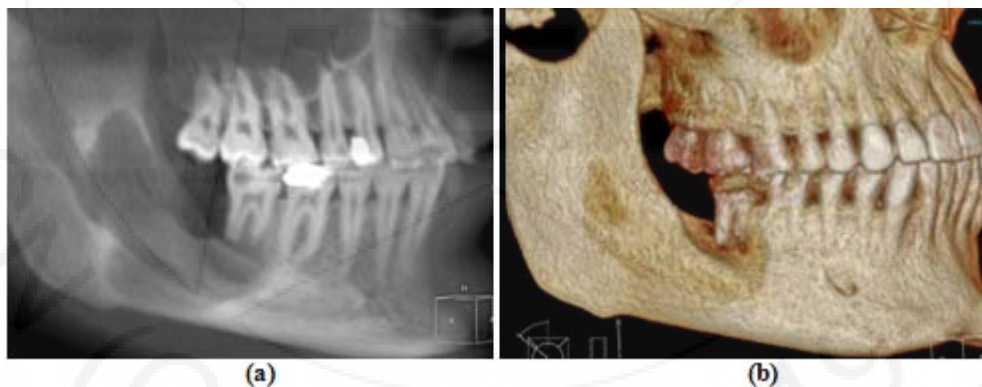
Preoperative CBCT. Sagittal slice (a) and 3D images (b) presenting the osteolytic defect from ameloblastoma in right mandible.
